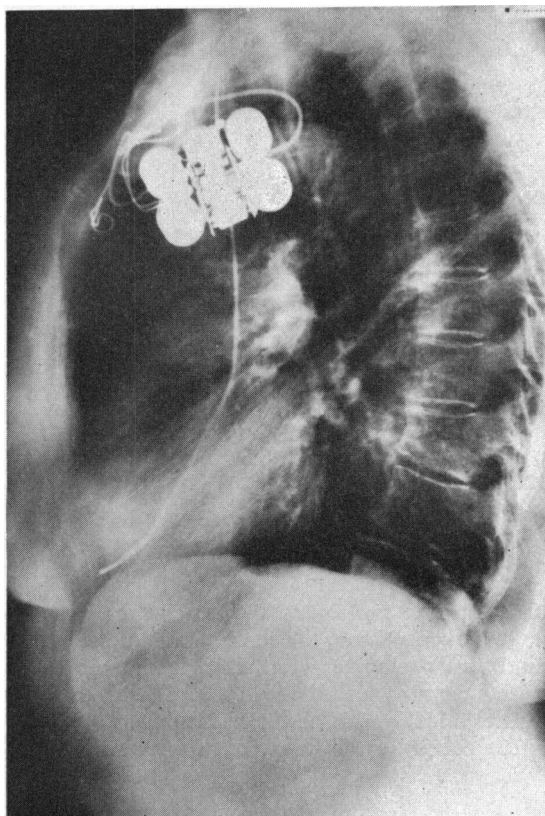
Lateral chest x-ray film showing the proximity of the endocardial electrode tip to the anterior chest wall.
